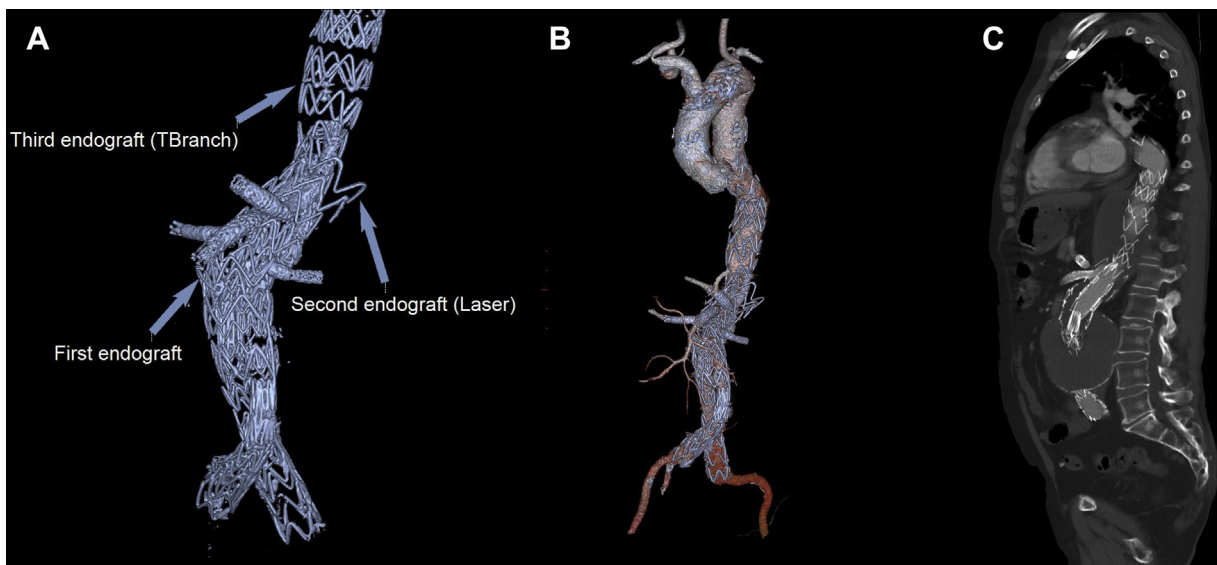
Computed tomography (CT) scan at 6-month follow-up after thoracoabdominal multibranch endograft implantation inside the previous endograft: total exclusion of the aneurysm with three-dimensional volume rendered reconstructions (A and B) and sagittal view (C). This shows a total of three endografts deployed one inside the other.
